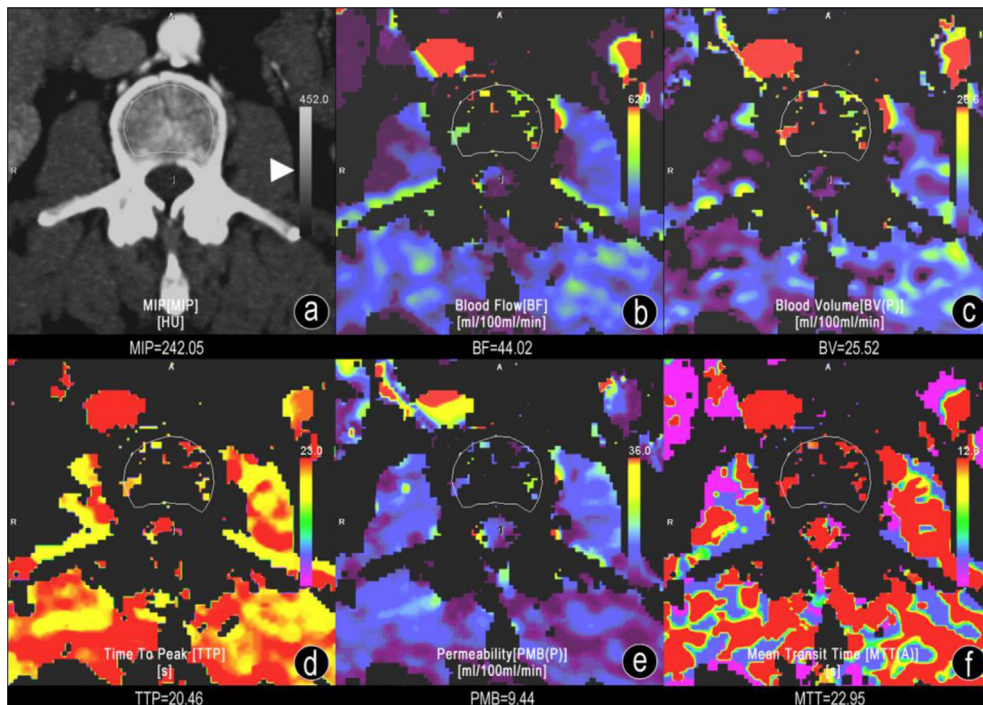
CTP assessment of the third vertebral body. Images from one of the slices obtained by dynamic perfusion using CT on the third vertebral body of a female with 28 years old. a: a ROI was manually drawn along the subcortical zone of the target vertebral body for calculation of the CTP parameters. b: the blood flow (BF) map of the CTP. c: the blood volume (BV) map. d: the time to peak (TTP) map. e: the permeability (PMB) map. f: the blood flow (BF) map. Three ROIs slices respectively selected from the site of upper one-third, middle and lower one-third of the third vertebral body were assessed. The CTP parameters (CTPs) values were averaged across these three slices and the mean was regarded as the actual CTPs values of the target vertebral body. The colored scales (triangular arrowhead) were designed automatically by software to shows how the perfusion of the ROI were similar to that of the outer tissue.
